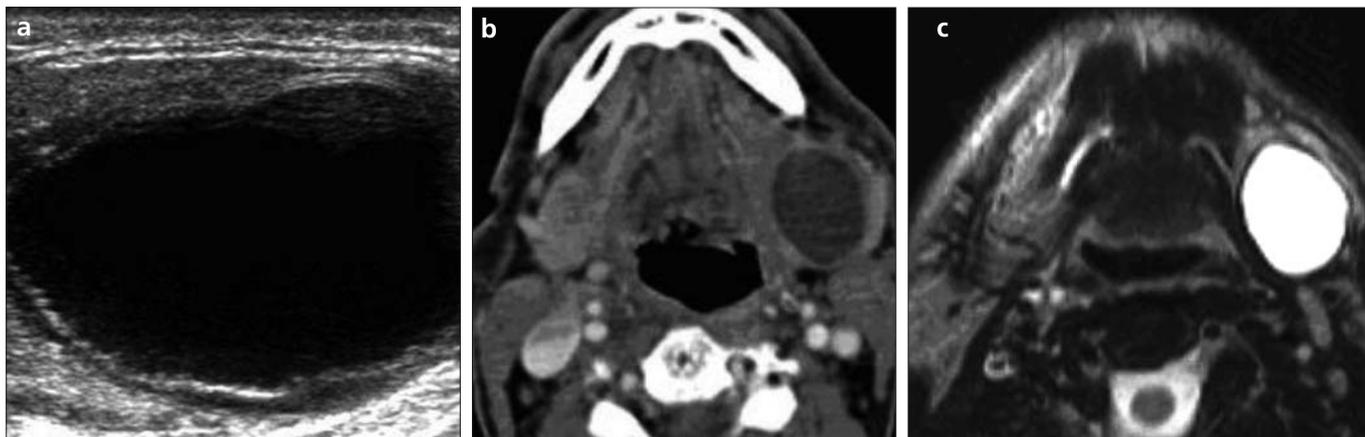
a–c. US image (a) showing left submandibular gland cystic lesion with double membrane appearance. Axial CT (b) and T2-weighted MR (c) images show the thick-walled cystic lesion in the left submandibular gland (type 1 hydatid cyst).
